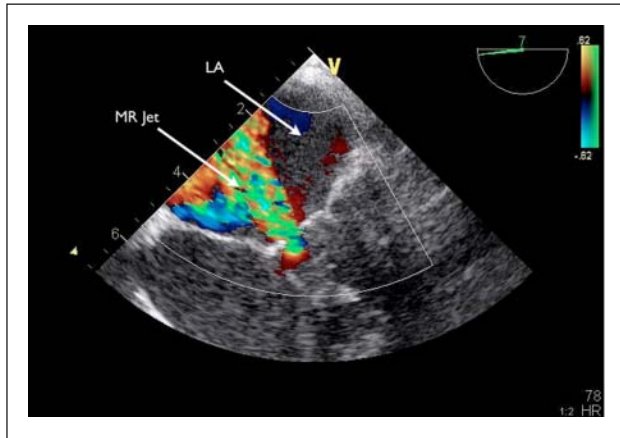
Mid-esophageal transesophageal echocardiography color Doppler interrogation of the mitral valve. Severe mitral regurgitation (MR) is seen in this patient with acute left ventricular ischemia. LA, left atrium.
